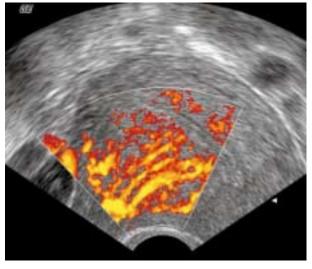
Normal vascular architecture on power Doppler which is diagnostic for adenomyosis and which rules out the diagnosis of myoma.
